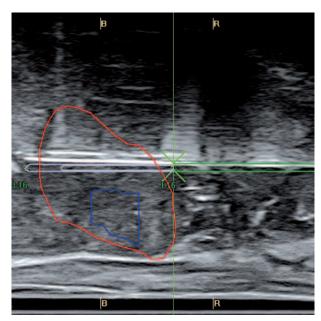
Image fusion with mixed images (MRI – U/S) in the top row and ultrasound only in the bottom row
